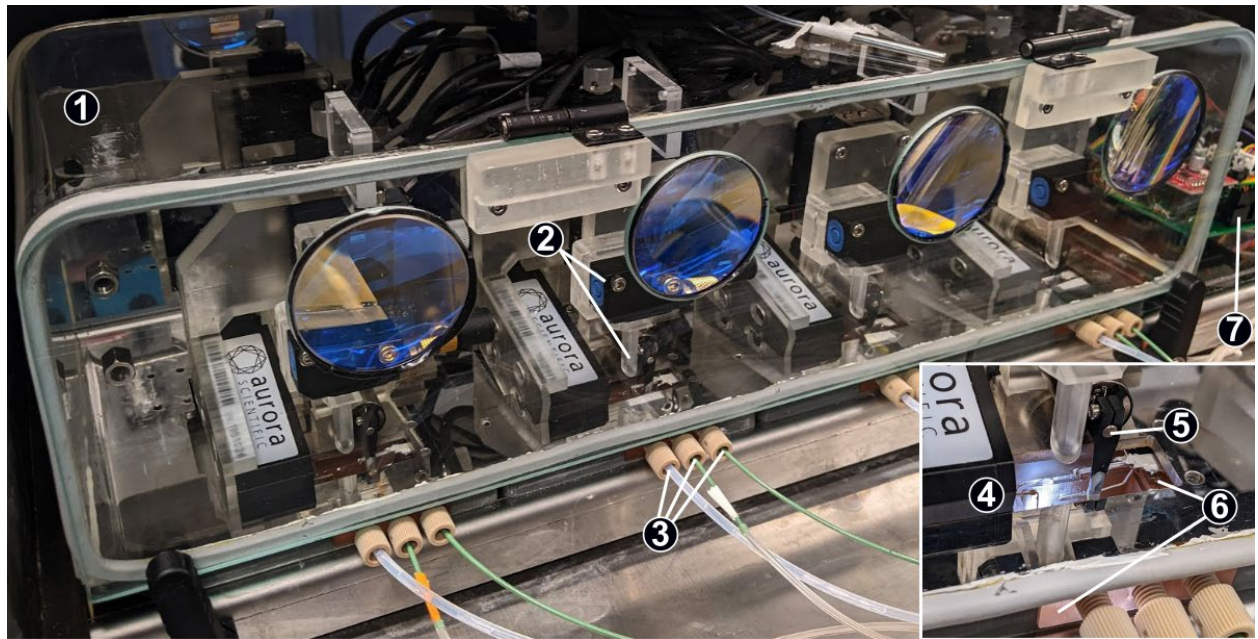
System overview. Inset: muscle bath. 1: Incubation chamber; 2: Ultrasonic distance transducer and focus tube; 3: Fluid connectors (left-to-right: waste, incubation medium and mechanics medium); 4: Force transducer; 5: Length actuator; 6: Fluid manifold; 7: Controller board.
